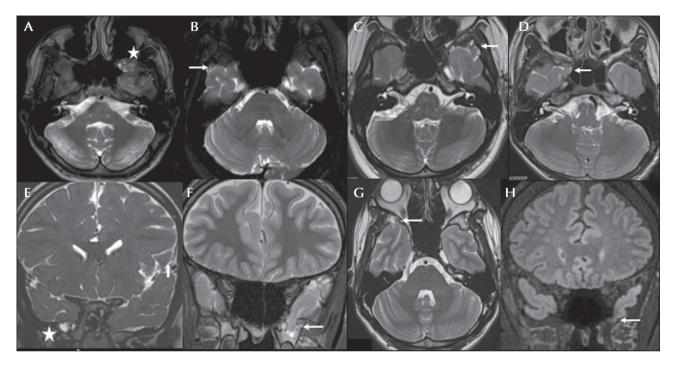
(A) T2 axial image showing a left encephalocele (star) (Case 2). (B) T2 axial image showing a right encephalocele (arrow) (Case 3). (C) Axial T2 image showing a left TE (arrow) (Case 4). (D) Axial T2 image showing a right TE (arrow) (Case 5). (E) Coronal T2 image showing a right TE (star) (Case 6). (F) Coronal T2 image showing a left TE (arrow) (Case 7). (G) T2 axial image showing a right TE (arrow) (Case 8). (H) FLAIR coronal image showing a left TE (arrow) (Case 9).
